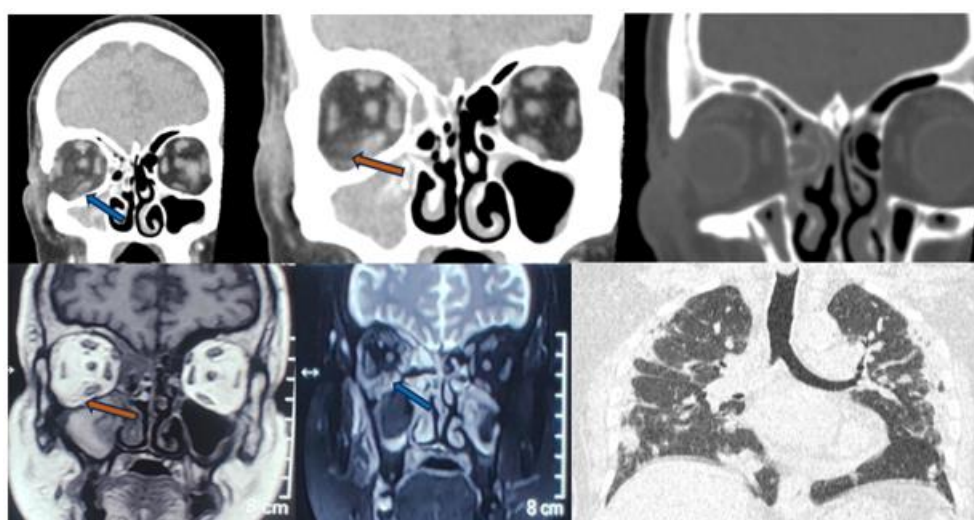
Plain CT showing inferior rectus edema (blue arrow) with adjacent fat stranding (orange arrow). HRCT chest showing ground glass opacities and fibrotic opacities S/O COVID-19 sequelae. T1WI and T2FS images showing right inferior rectus edema (blue arrow) with adjacent fat stranding (orange arrow).
